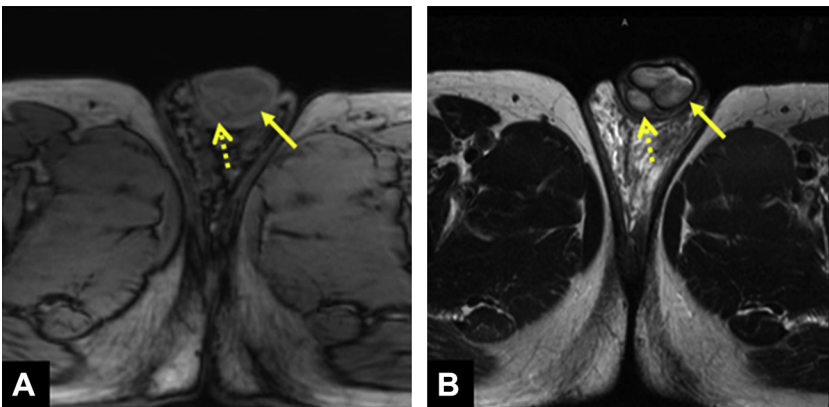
Normal penis. (A) Axial T1-weighted image shows intermediate signal intensity of the corpus cavernosum (*arrow*) and spongiosum (*dotted arrow*). (B) Axial T2-weighted image shows high signal intensity of the corpus spongiosum (*dotted arrow*) and heterogeneous signal intensity of the corpus cavernosum (*arrow*).
